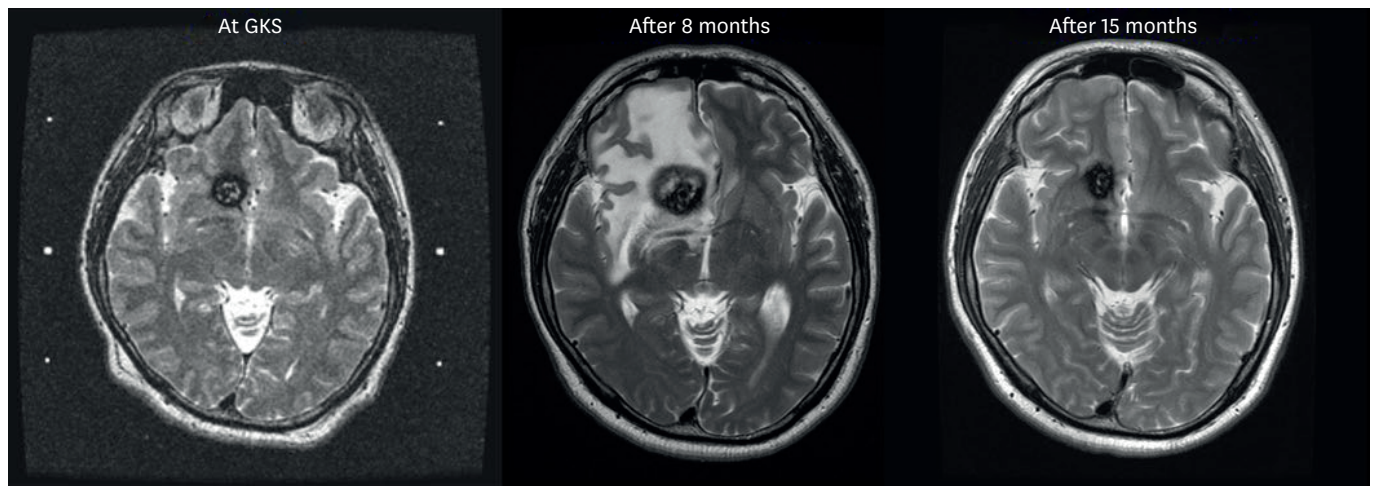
Shrinkage of lesion after extensive perilesional edema in brain MRI. A 2.3 cm³ cavernous malformation in the right frontal lobe was detected in a patient presented with seizure. GKS was performed with a marginal dose of 17 Gy to the 50% isodose line. After 8 months of GKS, the patient presented to the emergency room with severe headache. Extensive perilesional edema with increased volume of cavernous malformation due to hemorrhage was found in brain MRI. The patient received short-term steroid therapy. At 15 months after GKS, the perilesional edema disappeared completely and the volume of cavernous malformation was significantly reduced.
